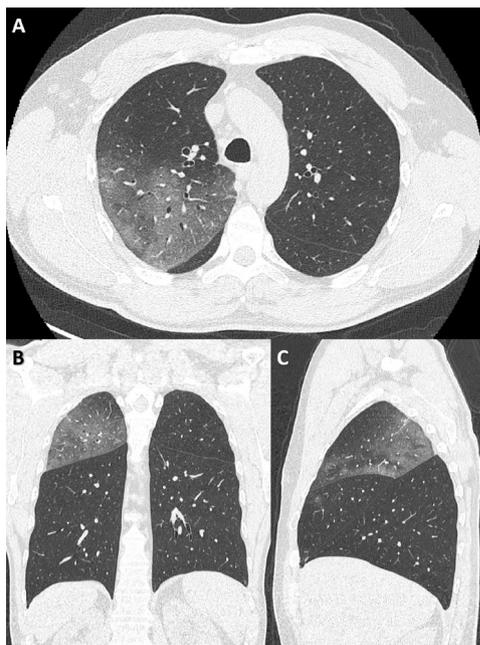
CT scan showing upper lobe COVID-19, bound by its fissures, in the transverse plane (A), coronal plane (B) and sagittal plane (C).
